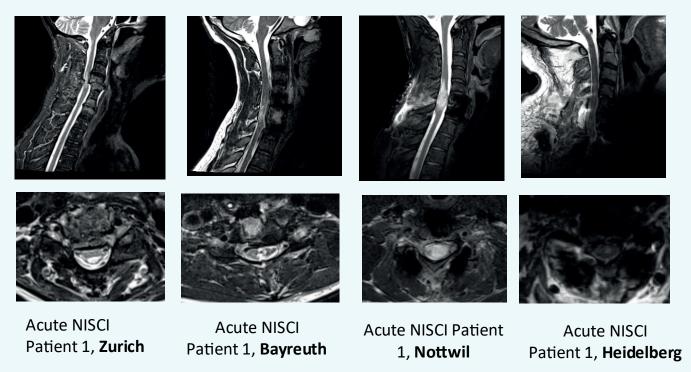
Overview of the lesion bridges at baseline ←14 days post SCI in NISCI patient with traumatic cervical spinal cord injury. Sagittal and axial T2-weighted scans show the cervical cord lesion from SCI patient recruited in Zurich, Bayreuth, Nottwil and Heidelberg.
